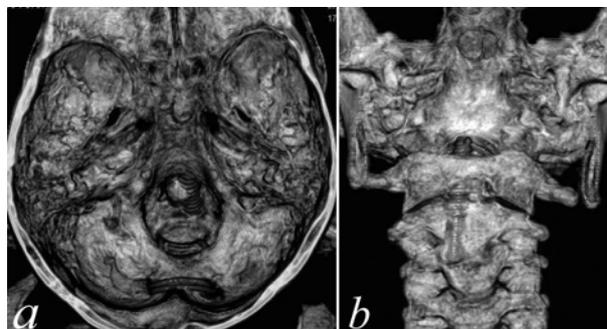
a, b. CT 3-D reconstruction scans shows type II dens fracture non-union managed with modified posterior occipitocervical fusion followed by direct odontoid screw fixation. The screw was placed laterally, not entirely within the body of the odontoid process and extending 2 mm beyond the tip of the dens. The patient was not reoperated and showed excellent results without complications on a follow-up
